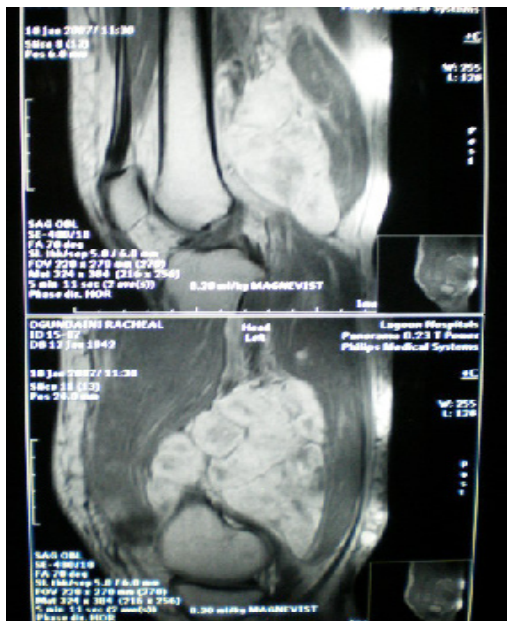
Another MRI film showing the tumour.
